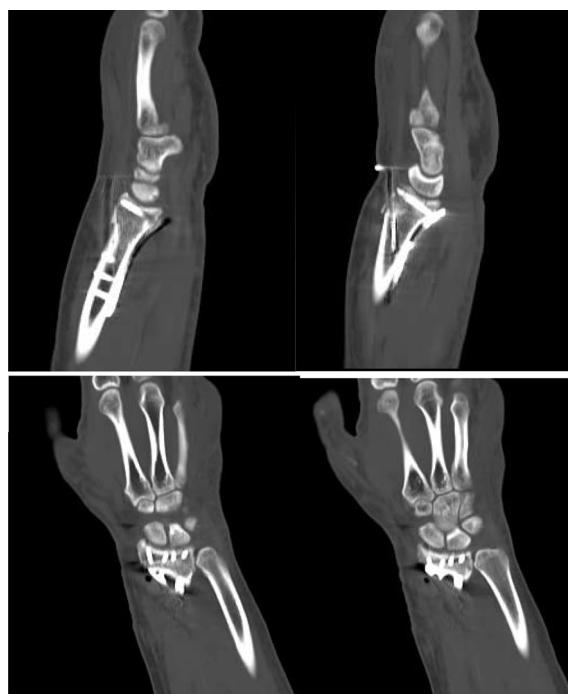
CT SCAN showed that the articular surface was smooth and the position of plate and screw was satisfactory
